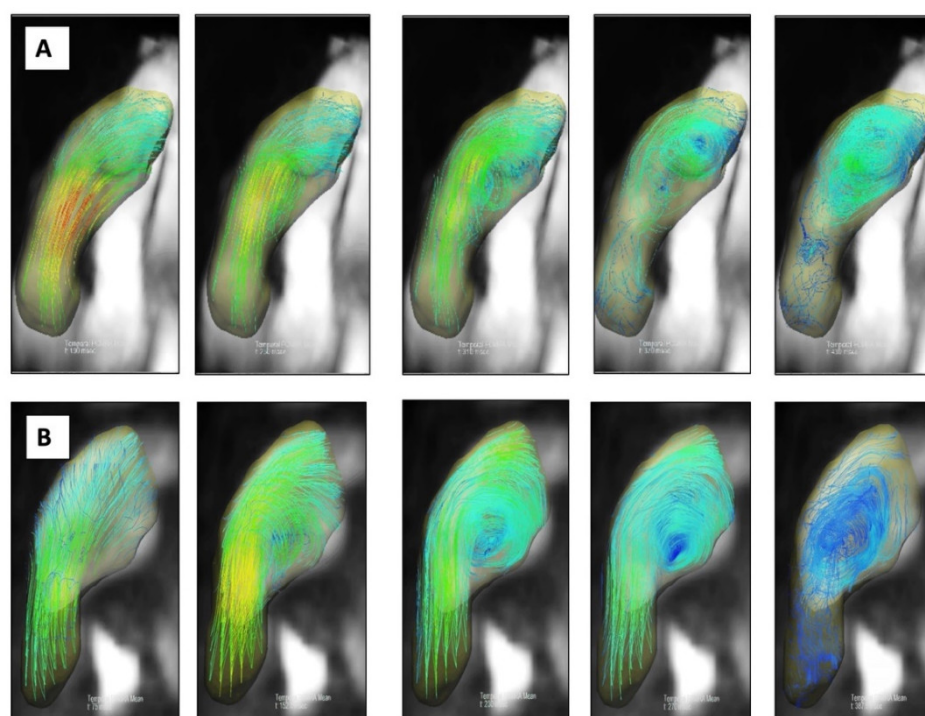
Examples of two patients with CTEPH, PH and vortical flow on 4D flow MR images. Patient 1 ((A) first image row) exhibited a vortical flow within pulmonary artery, detected during 60%
